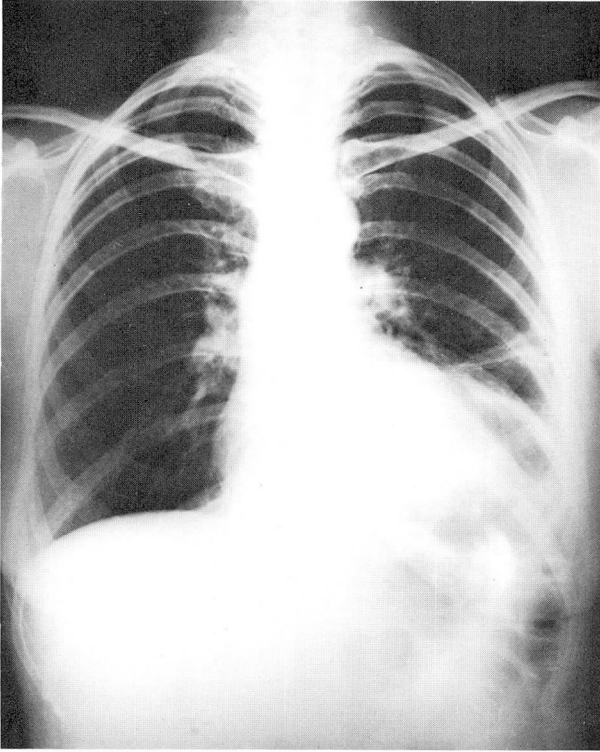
A posteroanterior roentgenogram of the chest and upper abdomen on January 13, 1965, with the patient standing. No free peritoneal air is evident. Pleural reaction obscures the left lower lung and left hemidiaphragm. (Courtesy of Charles E. Staats, M.D., Charleston, West Virginia.)
